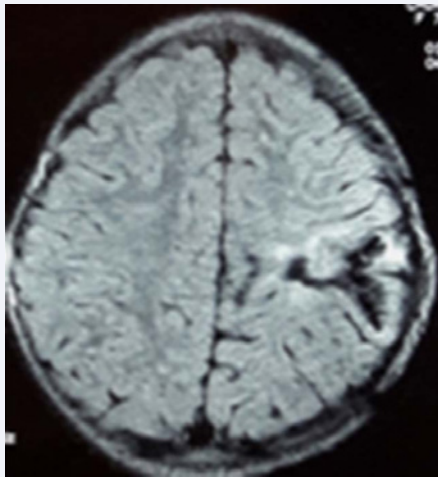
Cerebral MRI: FLAIR axial image showing no recurrence of the cyst.
